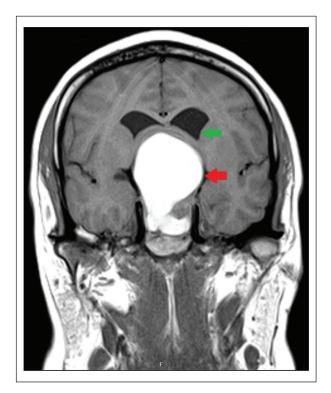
Preoperative MRI pituitary showed a large precontrast TI hyperintense sellar-suprasellar cystic and solid mass lesion causing mass effect (red arrow) and upward deviation of the optic chiasm. There is effacement of the lateral ventricles without obvious hydrocephalus (green arrow). MRI: magnetic resonance imaging.
